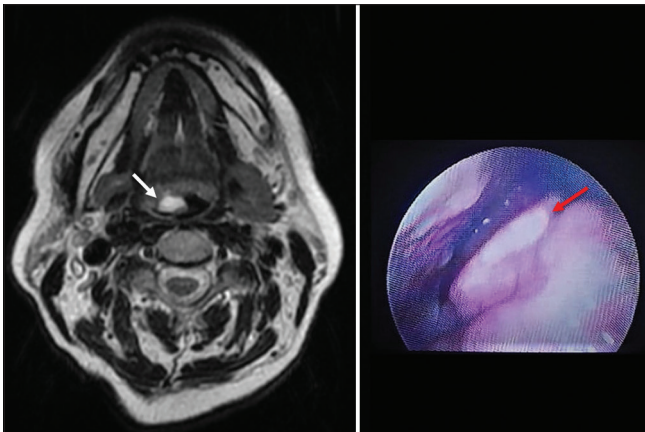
Left image: axial T2 fast spin echo magnetic resonance imaging image of the neck, which shows a high signal cyst next to the right side of the base of the tongue (white arrow) corresponding to the known epiglottic cyst. Right image: endoscopic view of the epiglottic cyst (red arrow) on the lingual surface of the epiglottis.
